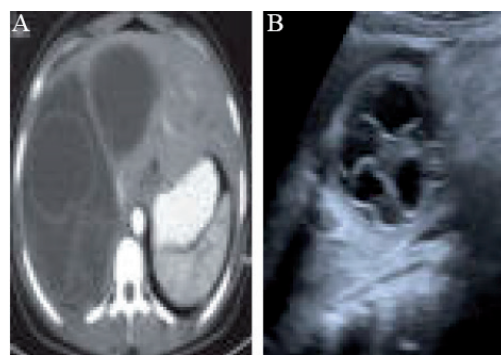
Type 3 hydatid cyst: (A) contrast enhanced computed tomography presents type 3 hydatid cyst in the right lobe of the liver and (B) oblique ultrasonogram shows anechoic lesion with membranes floating on the cyst fluid.
